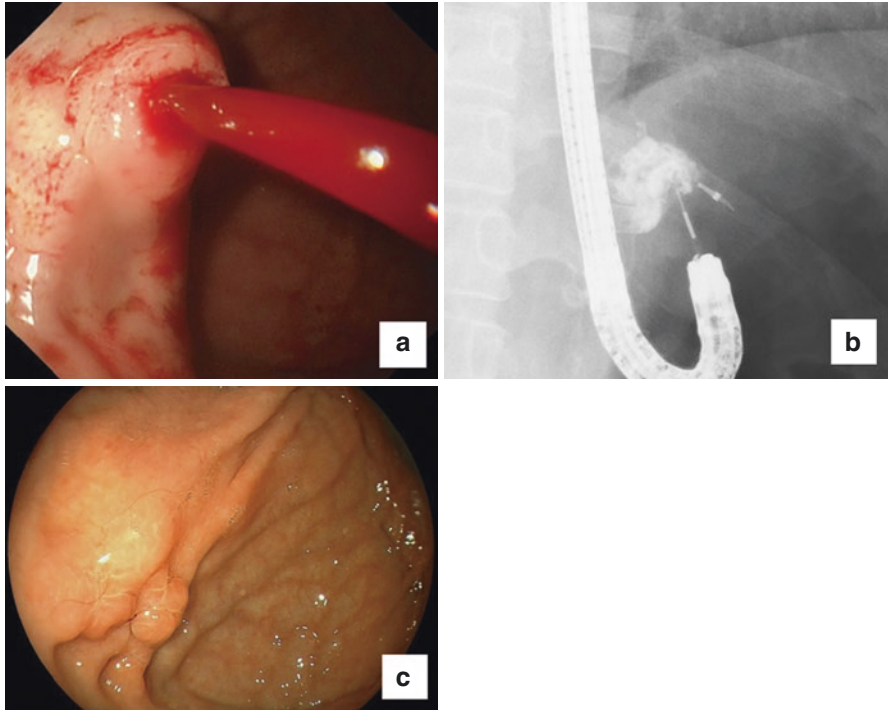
(a) Endoscopic appearance of blood spurting from a small fundal varix. (b) X-ray varicography showing that the varicose vein has been completely occluded after two endoscopic injections of a mixture of Histoacryl and Lipiodol. (c) Endoscopic image obtained at 6 postoperative months showing a completely eradicated GV
